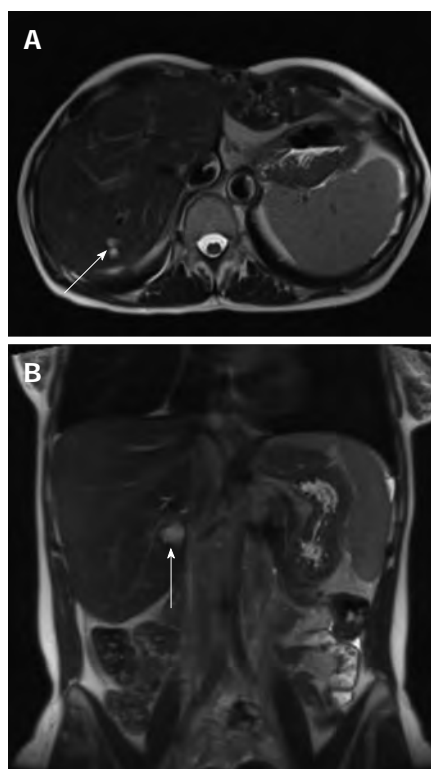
Follow up magnetic resonance imaging axial (A) and coronal (B) balanced gradient echo sequences (True FISP; Siemens Medical, Erlangen, Germany) through the liver performed as part of routine annual tumor surveillance at 1 year following venoplasty of the hepatic vein and inferior vena cava stenosis demonstrated normal appearance of the liver apart from simple parenchymal cysts (arrow). No ascites was seen.
